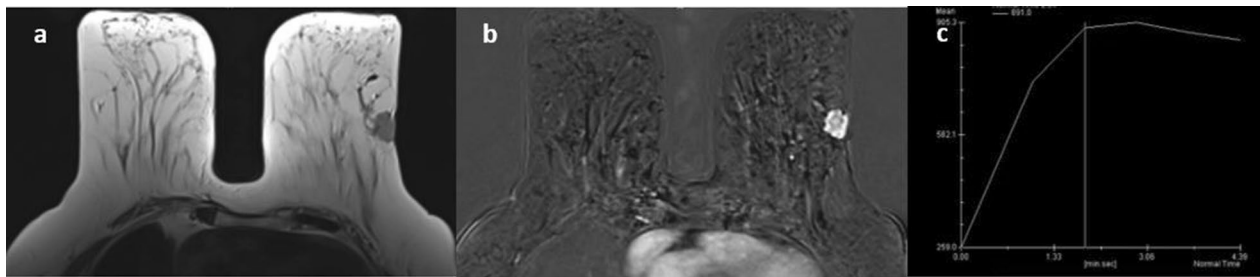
A 65-year-old patient presented with left breast lump, pathologically proven to be invasive ductal carcinoma, NOS, grade III and triple-negative type. ITGB1 FC = 10.41 a MRI T2WIs iso-intense rounded mass lesion with irregular margin. b T1 fat-suppression post-contrast subtracted image displays a left subcutaneous mass lesion with ring enhancement. Possible skin invasion is seen. c Type II-time signal intensity curve. Normal MRI appearance of the right breast. The imaging features in keeping with triple-negative cancer are rim post-contrast enhancement and skin invasion
